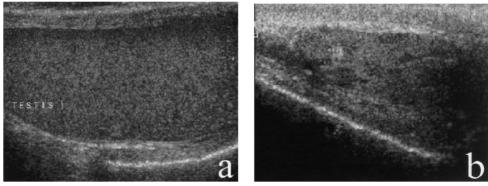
Longitudinal testicular sonography demonstrating characteristic homogenous parenchyma (score 1) of a man with normal sperm parameters (a) and typical heterogenous parenchyma (score 4) with hyperand hypoechoic foci of a man with nonmosaic Klinefelter syndrome (b).
